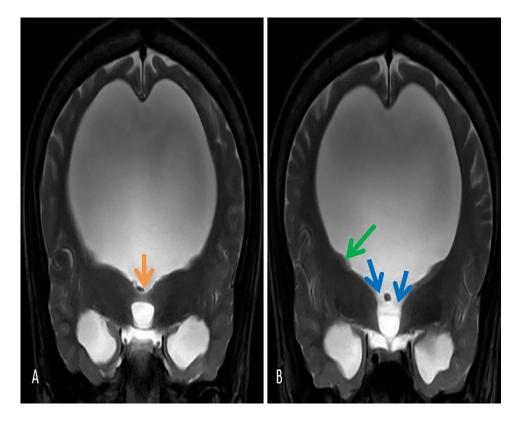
Magnetic resonance imaging of brain T2 weighted imaging coronal sections (A and B) shows nonfusion of bilateral thalami with interthalamic adhesion—Massa intermedia (orange arrow). Gross hydrocephalus with nonvisualization of cavum septum and wide communication of bilateral lateral ventricles with third ventricle (blue arrows). Subependymal nodule (green arrow).
